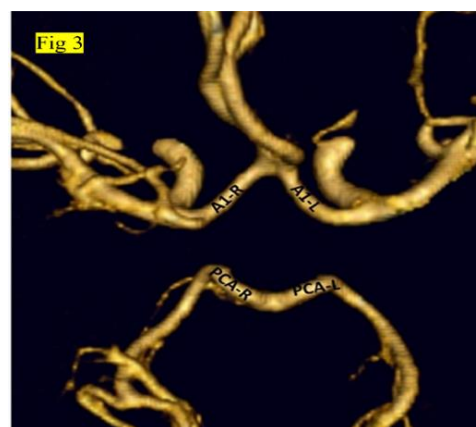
CT Angiographic image of absent bilateral PCoA
